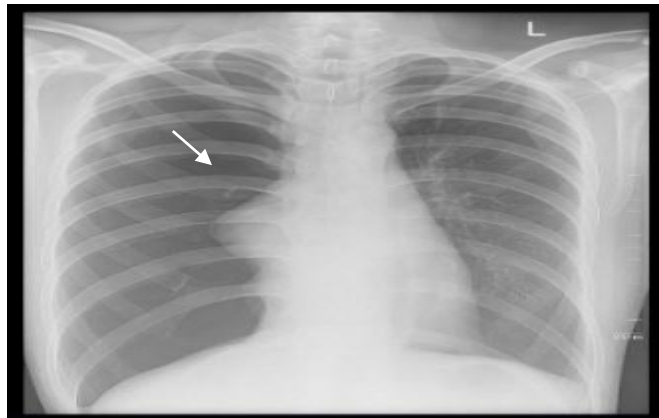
Chest X-ray demonstrates a diffuse avascular radiolucent area involving the entire right hemithorax, with a distinct pleural line consistent with right lung collapse (white arrow).
